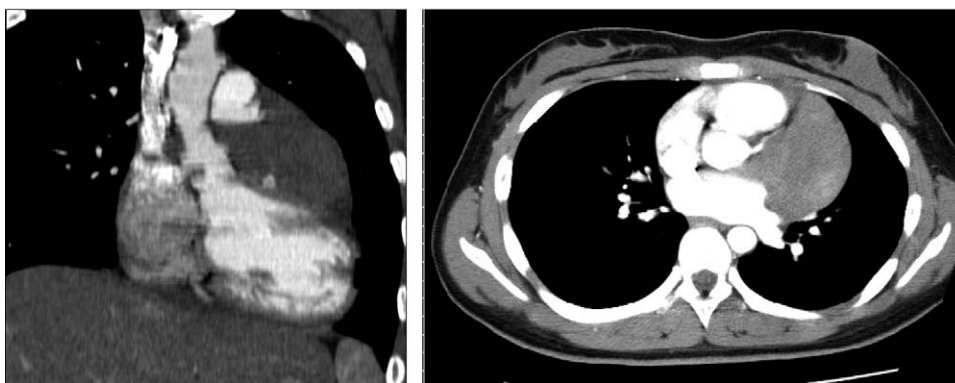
Computed tomographic scans showing large, heterogeneous mass compressing left ventricle in pericardium.
